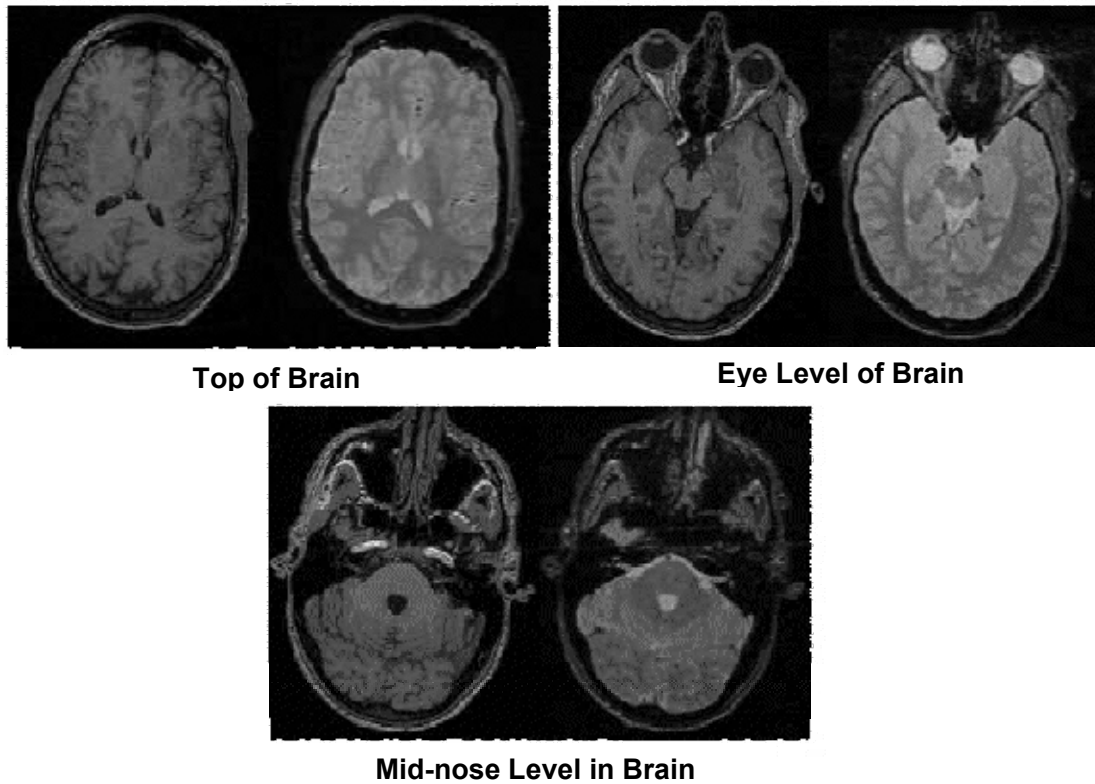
MRI images of the brain. T_1 -weighted (left) and T_2 -weighted (right).¹⁹⁶
